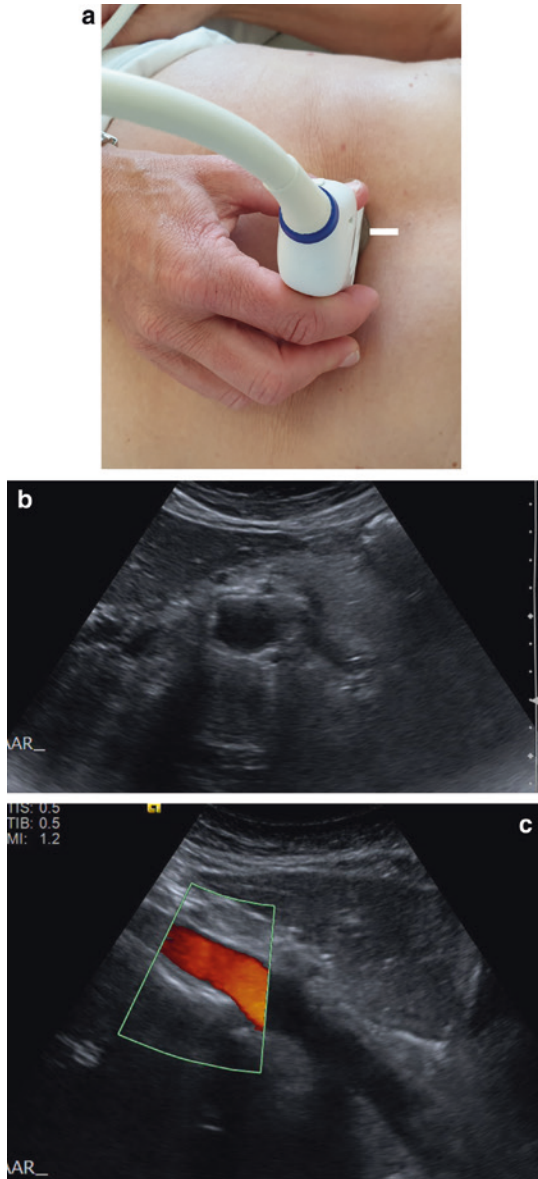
Examination of the abdominal aorta: a recommended transducer position, b ultrasonographic image, transverse view c ultrasonographic image, longitudinal view
